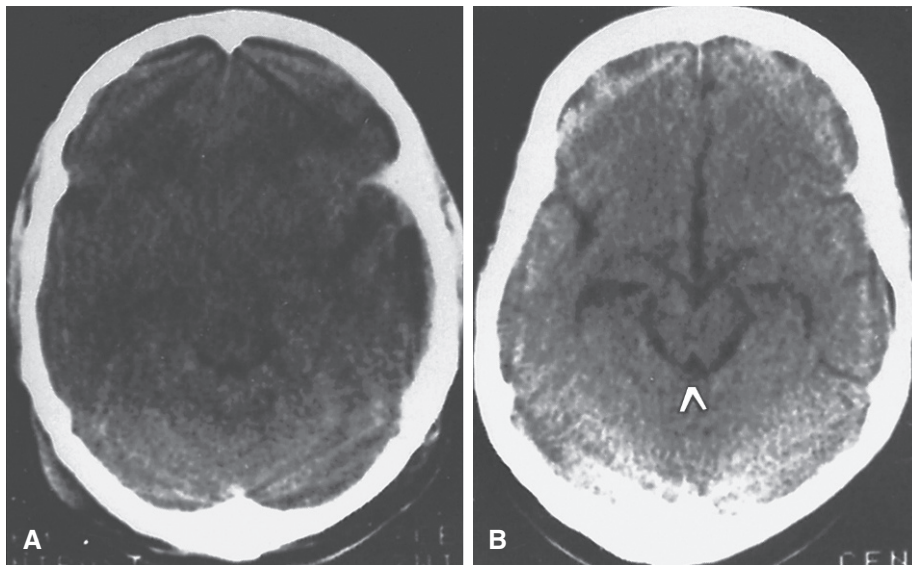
Computed tomography scans showing compressed basal cisterns (A) and normal basal cisterns (B, arrow). The presence of compressed basal cisterns after head trauma increases the risk of poor outcome. (From Toutant SM, Klauber MR, Marshall LF, et al: Absent or compressed basal cisterns on first CT scan: Ominous predictors of outcome in severe head injury. *J Neurosurg* 1984;61:691-694.)
